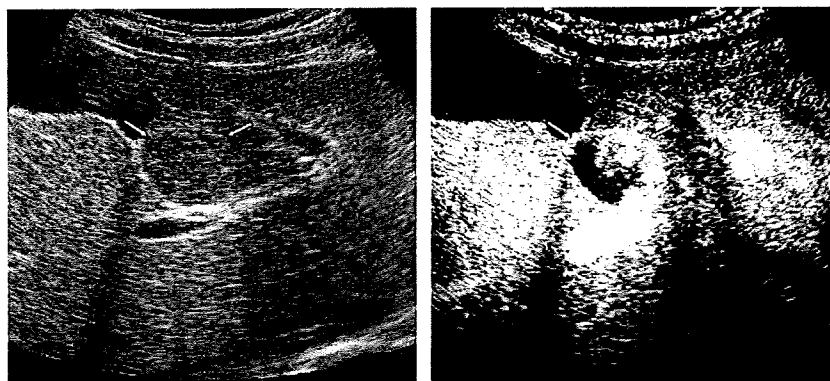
A 38-year-old woman with liver hemangioma (*arrows*). (a) Oblique subcostal B-mode ultrasound shows mass with hyperechoic rim (*arrows*). (b) In the arterial phase, the image shows peripheral puddles of contrast that were enhanced more than the adjacent liver parenchyma.
